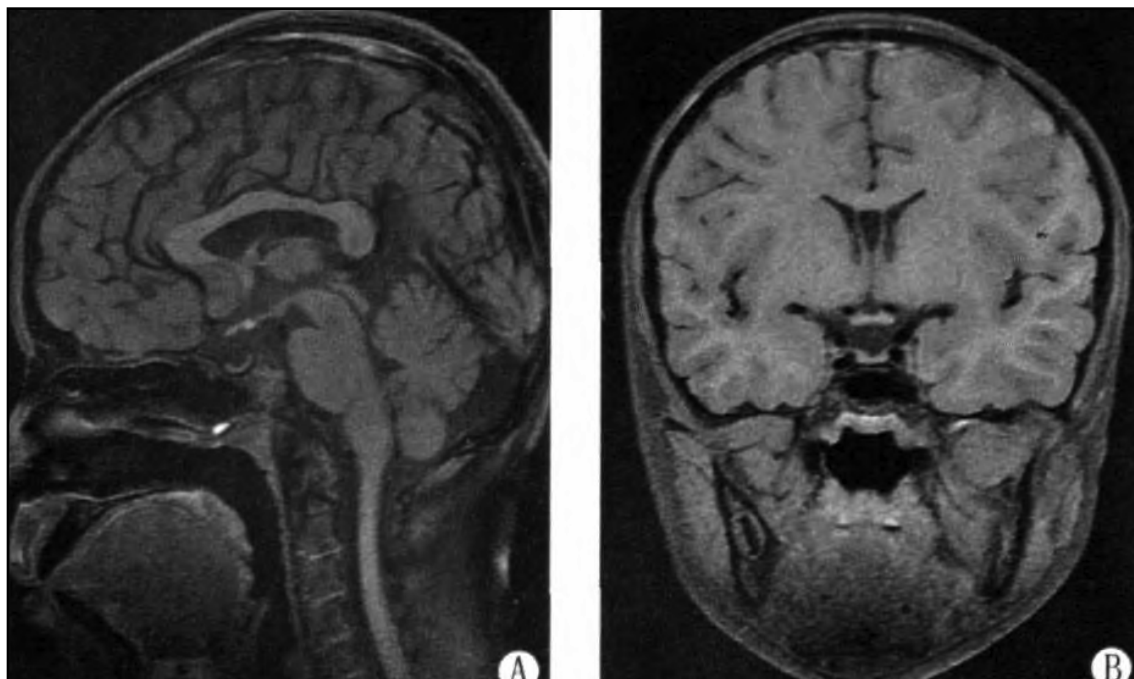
MRI imaging features of pituitary stalk interruption syndrome. On sagittal sequences T1WI plain scan, the hyperintensity of posterior pituitary disappeared, and the ectopic neurohypophysis located in the infundibulum recess of the third ventricle at the bottom of hypothalamus, showing nodular hyperintensity (A). On coronal sequences T1WI, the adenohypophysis became thinner and the pituitary stalk was not shown (B).
